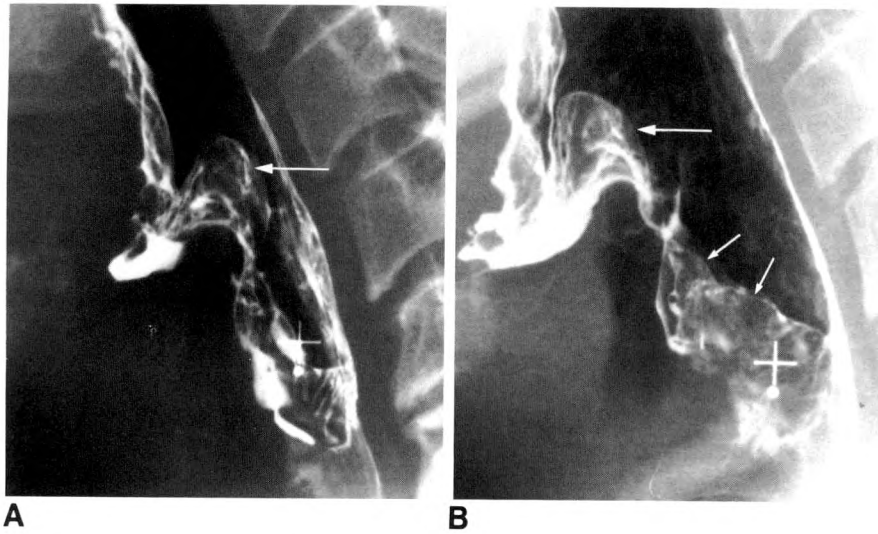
Lateral radiographs in 59-year-old man with squamous carcinoma of epiglottis.
